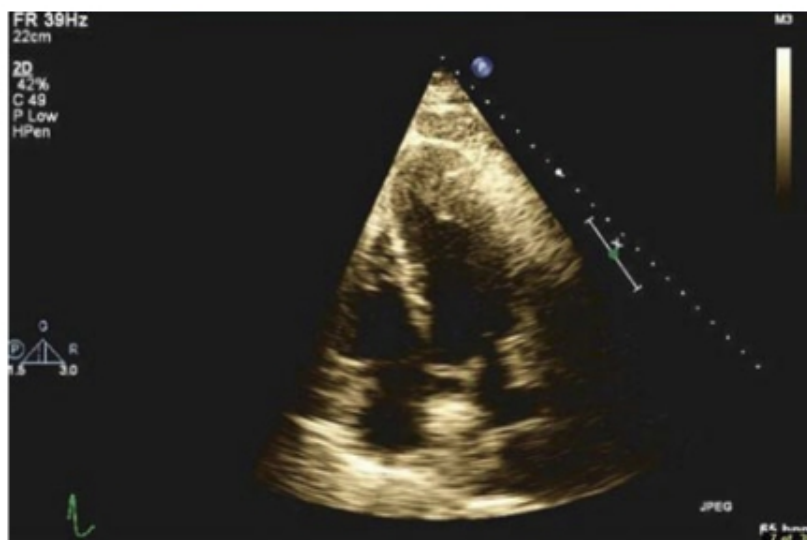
2-D echocardiogram of patient- Mild LVH with wall thickness of 1.5 cm mid apical septum. Normal left ventricular end-diastolic dimension of 4.1 cm (normal <5.5cm). LA enlargement with LA volume of 40 ml/m² (normal <28ml/m²). Mild mitral regurgitation. Image obtained from Yusuf SW, Bathina JD, Banchs J, Mouhayar EN, Daher IN. Apical hypertrophic cardiomyopathy. World J. Cardiol. [Internet]. 2011 Jul 26 [cited 2014 Apr 24];3(7):256–9. (22)
